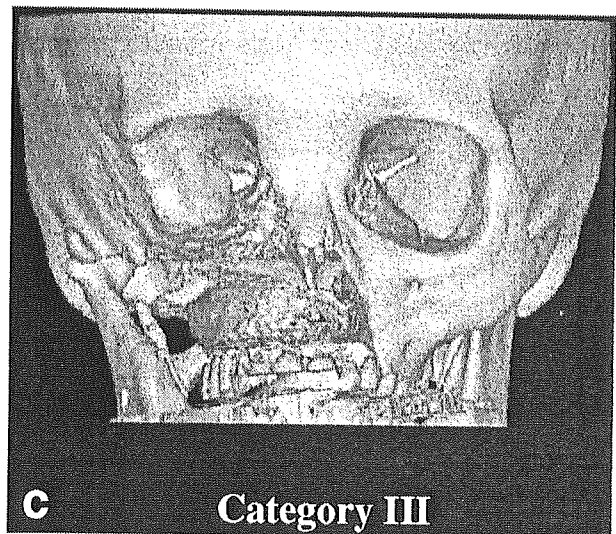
Three categories of maxillectomy defects shown in three-dimensional computed tomography (CT) scans. a Category I includes limited maxillectomy and subtotal maxillectomy defects. b Category II includes orbitomaxillectomy and orbitozygomaticomaxillectomy defects. c Category III includes total maxillectomy and extended total maxillectomy defects
